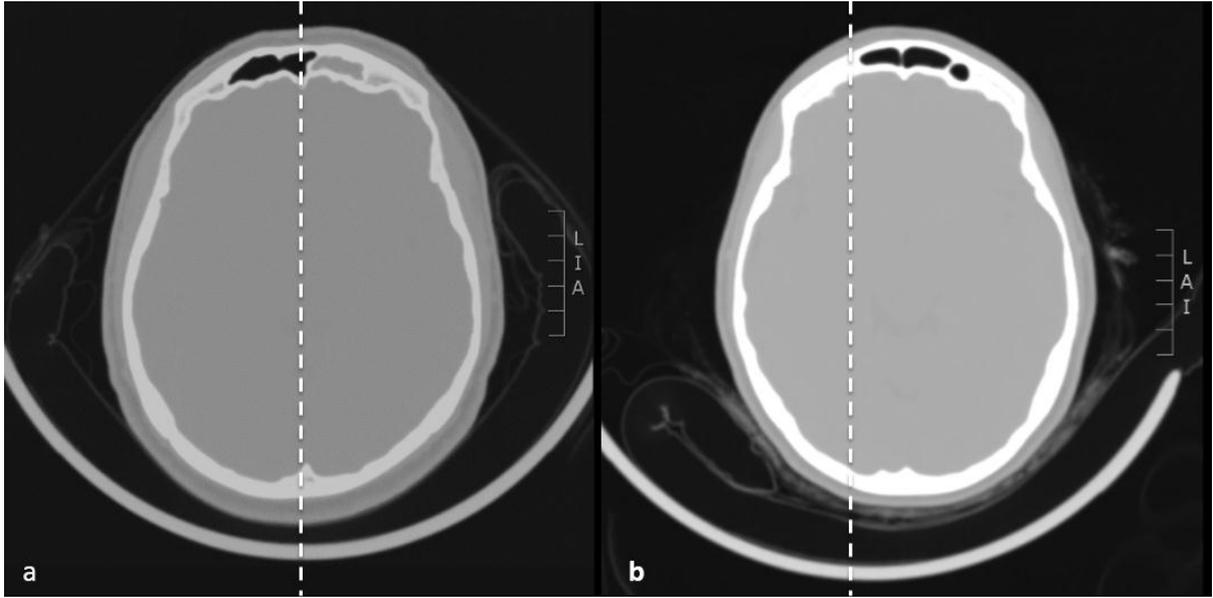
Optimal head centering (a) and sub-optimal head centering (b) during intracranial CT.
